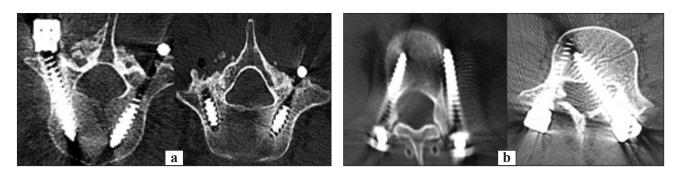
X-ray control of the location of the screws in the vertebrae: correct (a) and incorrect (b)
